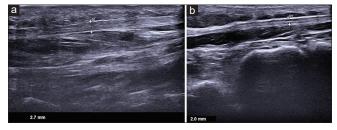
Sonographic images showing PF thickness in a DM patient (a) and a healthy volunteer (b). PF: Plantar fascia, DM: Diabetes mellitus
